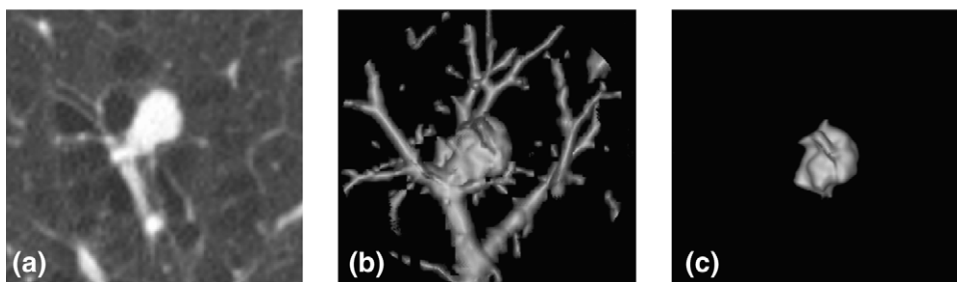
Segmentation of pulmonary nodules with minimal user interaction. An SPN is detected by the radiologist, and using advanced analysis tools (Advanced Lung Analysis, GE Medical Systems, Milwaukee, Wisconsin) the nodule is segmented automatically and the volume is determined. (a) Solid pulmonary nodule detected by the radiologist in an axial CT scan. (b) The Nodule and vessel structure are segmented from the parenchyma and displayed as a three-dimensional surface. (c) Nodule is separated automatically from the vascular structures and its volume is computed. (Courtesy of Lawrence Goodman, MD, Froedtert Hospital, Milwaukee, WI.)
